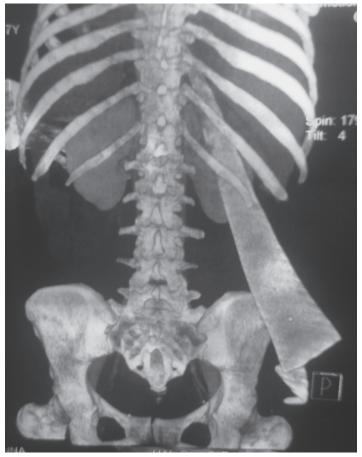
A reconstructed image of computed tomography of the thorax and abdomen with the patient in prone position, showing the piece of glass passing through the right kidney.
